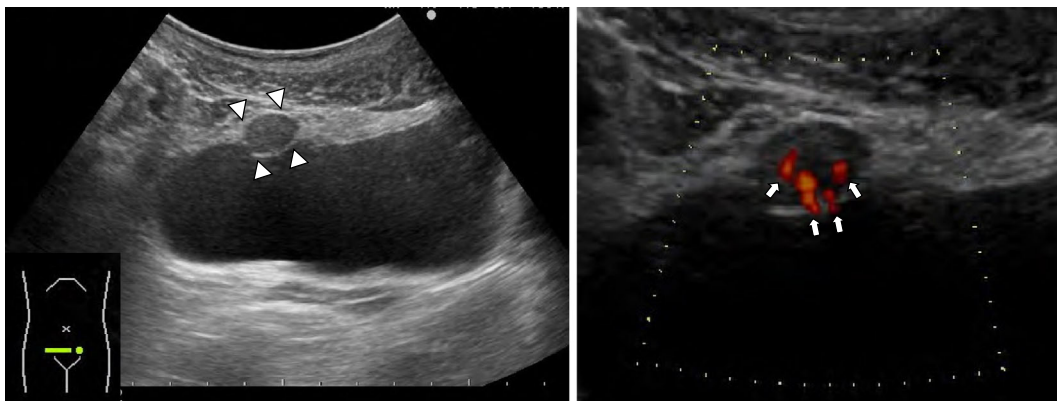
An abdominal ultrasonogram in the transverse section revealed a mass echo of 15×11 mm in diameter, located slightly to the right of the midline on the ventral side of the bladder wall (white arrowheads) (left panel). The signals of the blood flow in the mass could be seen in magnified image (white arrows) (right panel).
